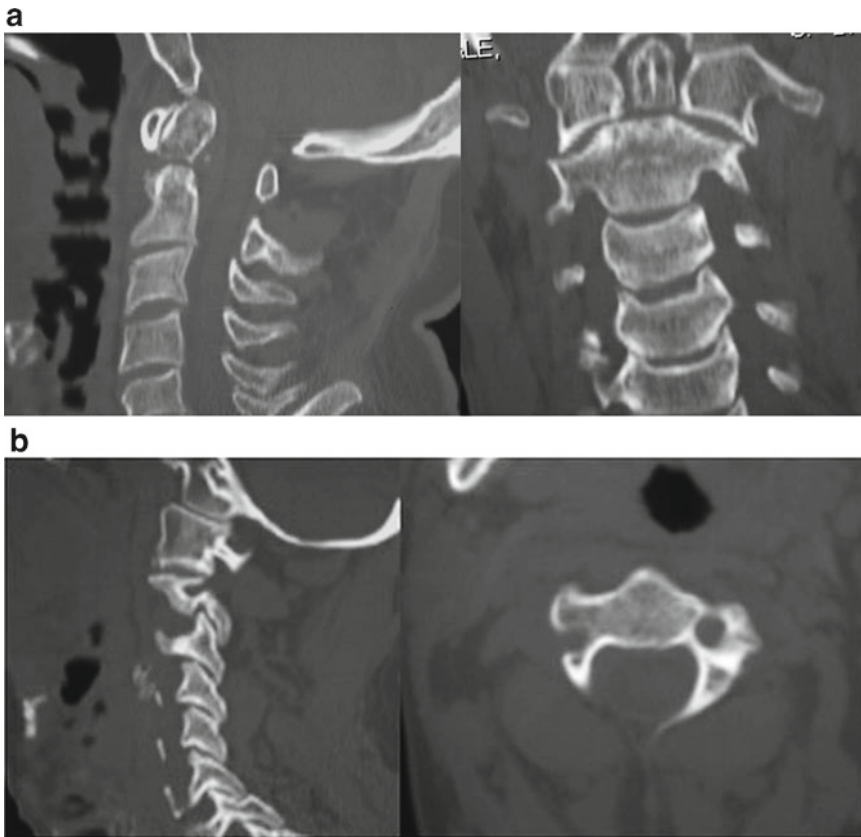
(a) Sagittal and coronal computerized tomography (CT) images revealing a Type II odontoid fracture. (b) Sagittal and axial computerized tomography (CT) images revealing high riding vertebral artery groove and a
